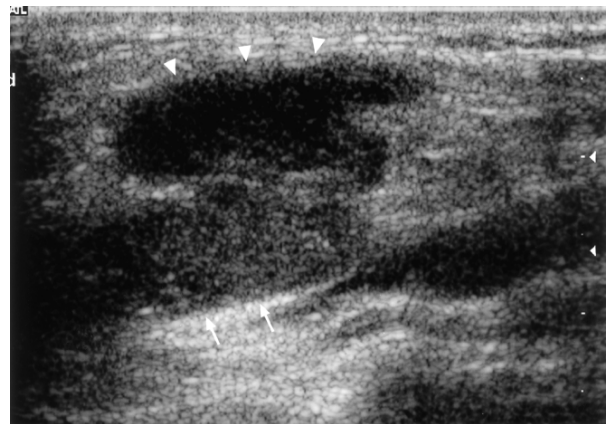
Sonogram of a hypoechoic node with ill-defined borders (arrows). Note the hypoechoic area adjacent to the lymph node (arrowheads) which indicates soft tissue oedema.
